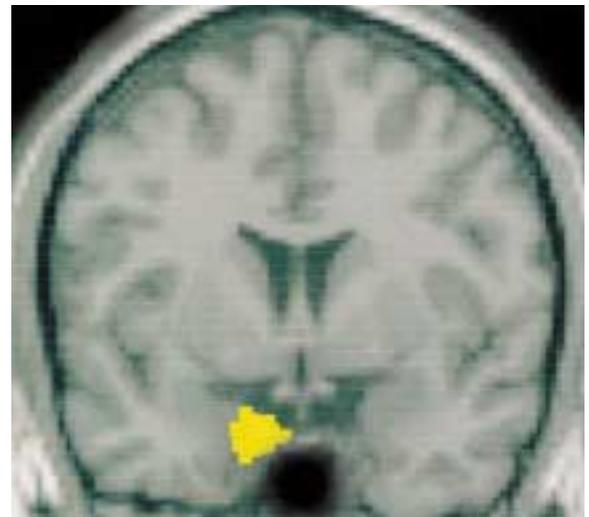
Left amygdala activity associated with successful intentional retrieval of emotional explicit memory for picture stimuli. The region of activation is shown in yellow, superimposed over an averaged coronal structural MRI section through the amygdala.
